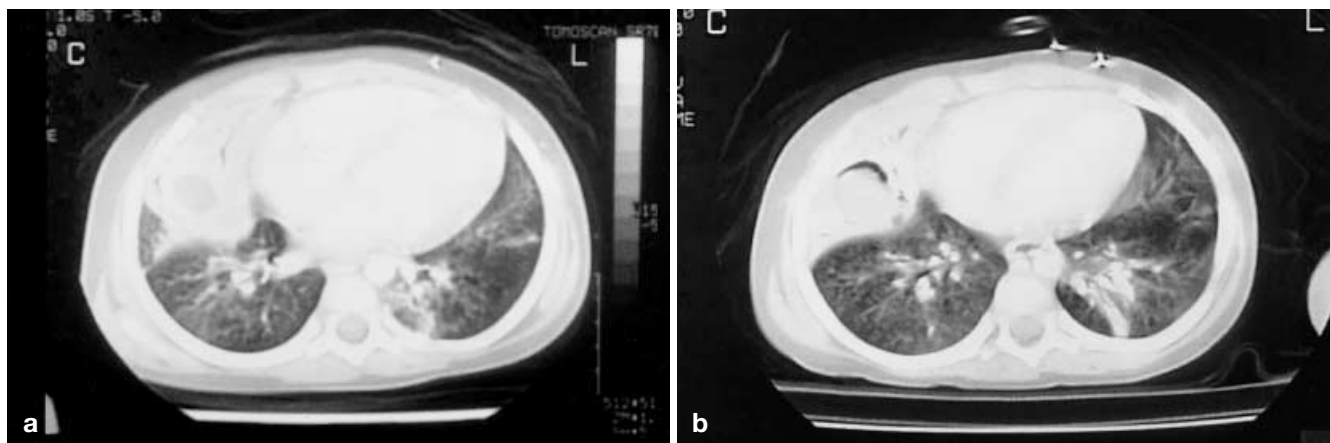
ARDS in haematological malignancy represents a particularly challenging diagnostic dilemma. The CT scan can detect signs of fungal infection much earlier than conventional chest X-ray imaging. In this 2-year-old girl with erythrophagocytic histiocytosis and pulmonary insufficiency, CT scanning revealed (a) two abscesses in the right lung and (b) one with an air contour. In the previous absence of positive microbiology or serology, CT localisation allowed percutaneous needle aspiration that revealed *Aspergillus fumigatus*
